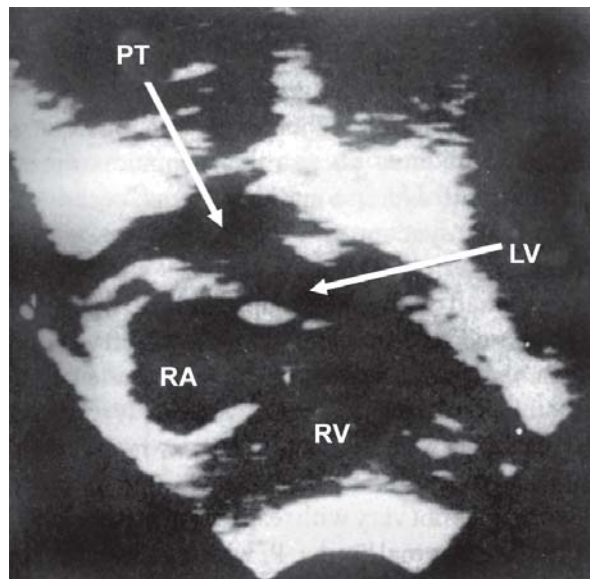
Echocardiography (two-dimensional) in TGA
